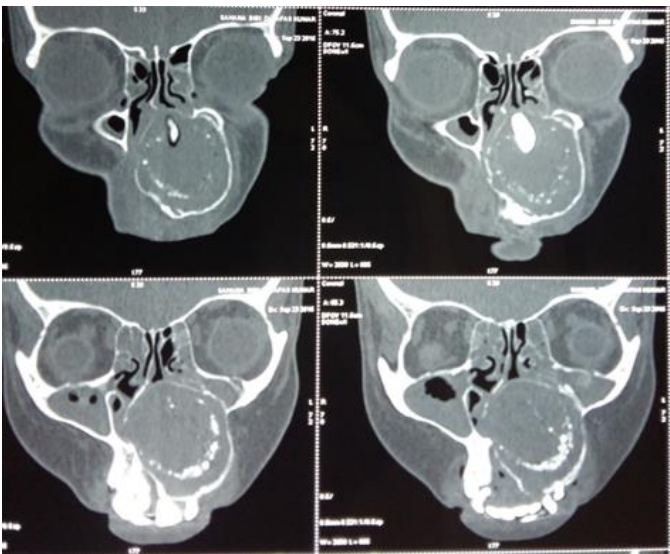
Orthopantomogram and Computed tomography in the patient.
